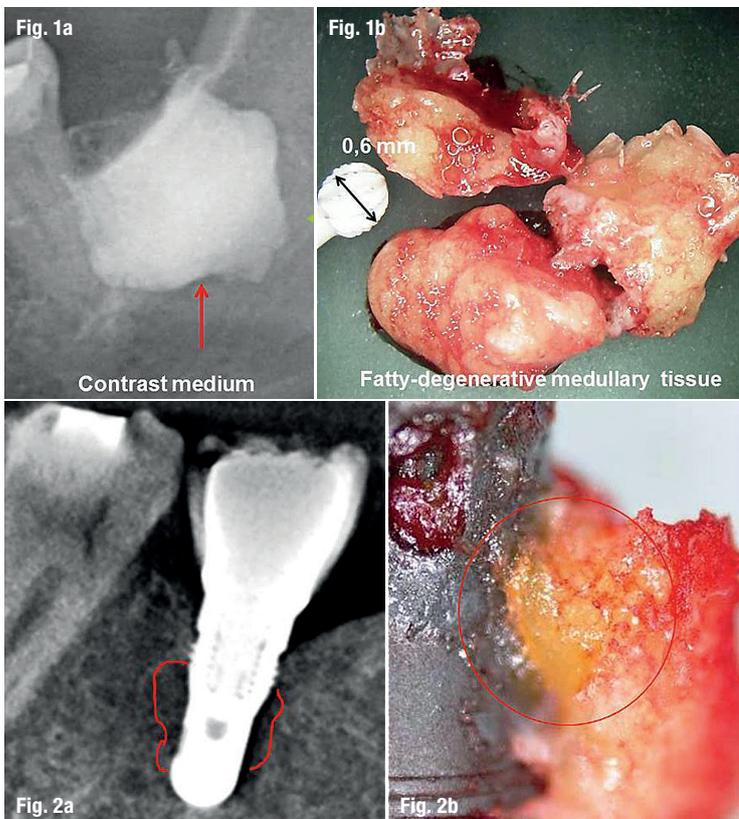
Contrast medium in affected cavity after curettage (a) and jawbone sample of fatty and osteolytic degenerated bone marrow (b). Fig. 2: Titanium implant in area #46 as shown in the CBCT scan (a); fatty-degenerated tissue attached directly to the titanium implant (b).
